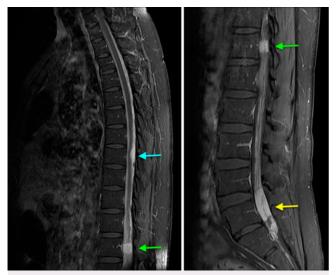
Sagittal MR images of thoracic (left) and lumbar (right) spine with contrast at time of tumor diagnosis, demonstrating metastases to T8 (*blue arrow*), T12 (*green arrows*), and L5 (*yellow arrow*).
